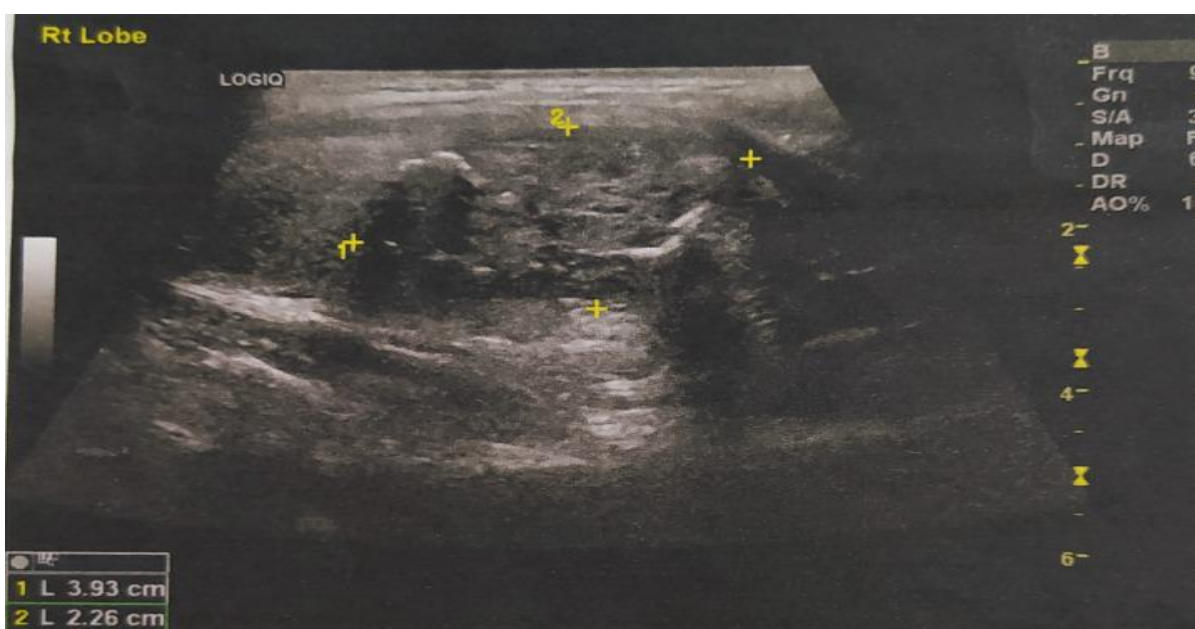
Ultrasound aspect of TN of inhomogeneous structure with liquid inclusions, hypoechoic, irregular margins, peripheral and central point calcifications (TI-RADS 5)
